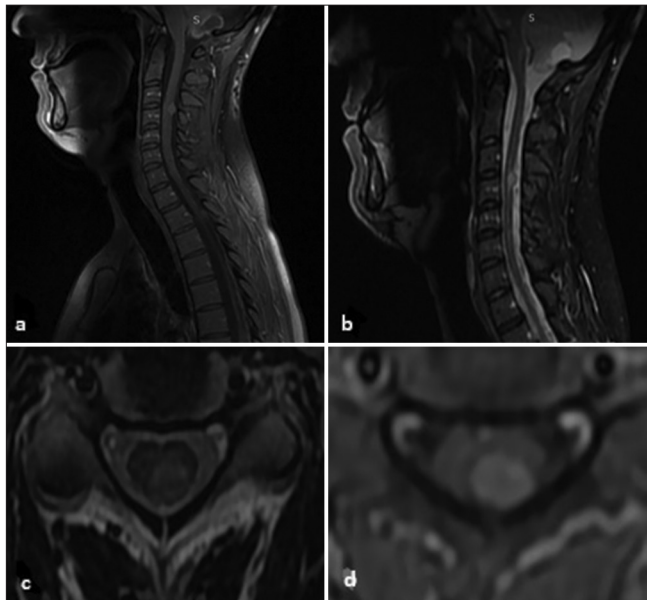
(a) sagittal T1-weighted and sagittal T2-weighted (b) revealed a hyperintense T2 mass and multiple subarachnoid lesions; (c) axial T2-weighted and axial contrast-enhanced T1-weighted (d) images of the cervical spine showed an enhancing tumor.
